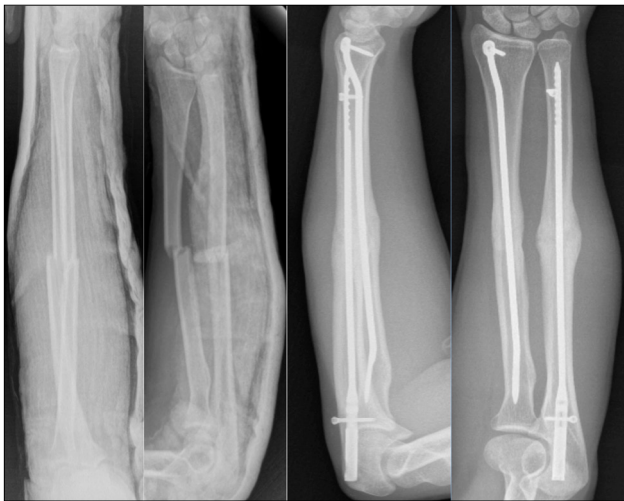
A 26-year-old male patient with a double fracture of the forearm after a fall while playing soccer. Intramedullary nailing (IMN) was performed on both bones. Preoperative and postoperative radiographs after union are presented.
